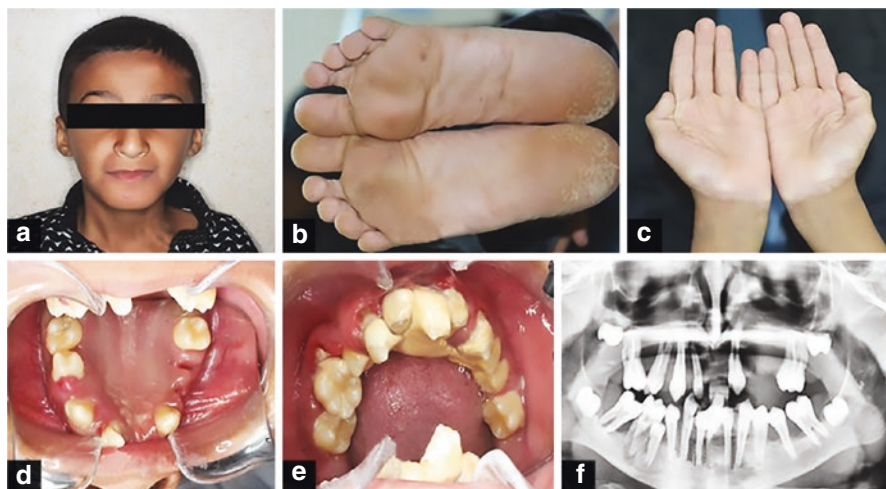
Characteristic clinical features of Papillon-Lefèvre syndrome. (a) An 11-year-old male patient; (b) plantar hyperkeratosis; (c) palmar hyperkeratosis; (d) maxillary arch teeth; (e) mandibular arch teeth; (f) orthopantomogram showing loss of multiple teeth and alveolar bone loss around many present teeth. (Reprinted with permission from reference [174])
